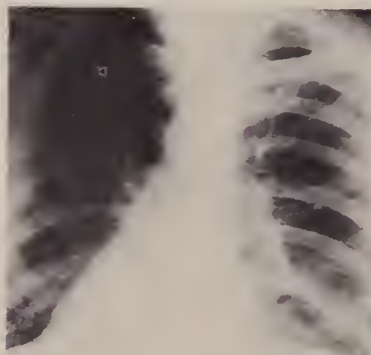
Case R. W. Radiograph of chest fifty-three days after admission. Febrile reaction for first nine days; temperature normal thereafter.
